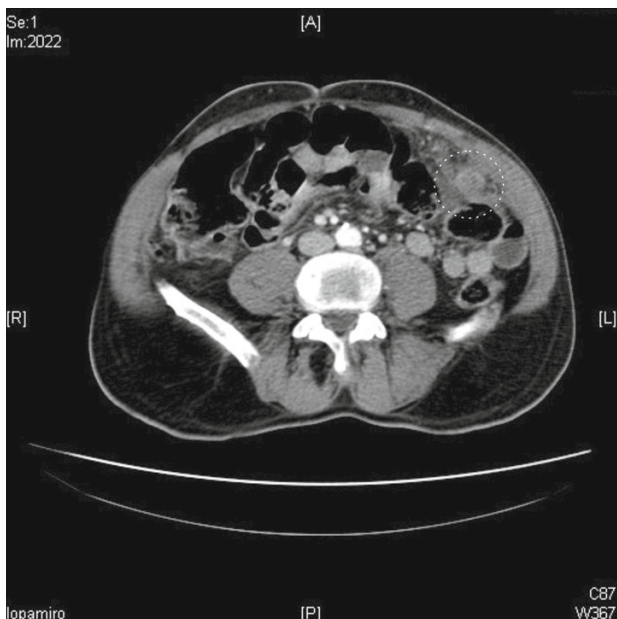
Computed tomography (axial view): Ovoid lesion 1.7 cm × 1.5 cm lesion with contrast enhancement after intravenous administration at the splenic flexure of the colon.
